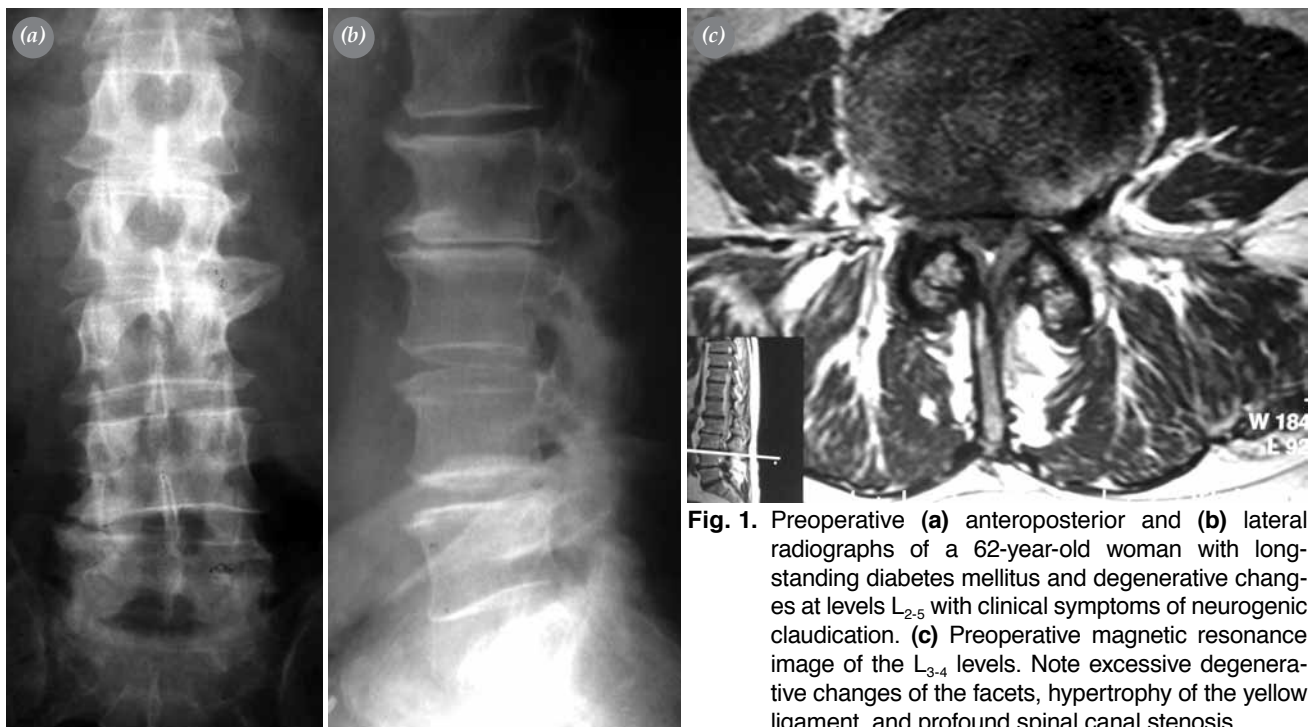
Preoperative (a) anteroposterior and (b) lateral radiographs of a 62-year-old woman with long-standing diabetes mellitus and degenerative changes at levels L₂₋₅ with clinical symptoms of neurogenic claudication. (c) Preoperative magnetic resonance image of the L₃₋₄ levels. Note excessive degenerative changes of the facets, hypertrophy of the yellow ligament, and profound spinal canal stenosis.
